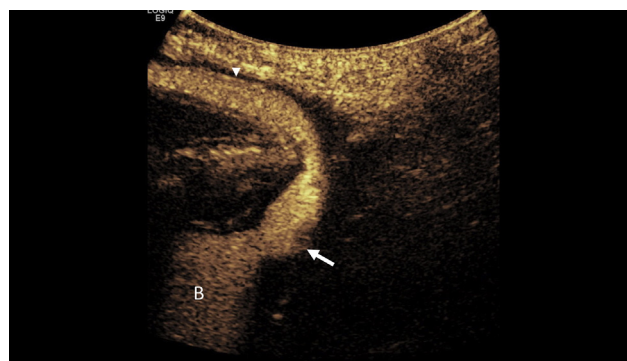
Transperineal image of urethra. Good visualization of urethra demonstrated during voiding on contrast-enhanced ultrasound. Bladder (B), posterior urethra (arrow), anterior urethra (arrowhead).
